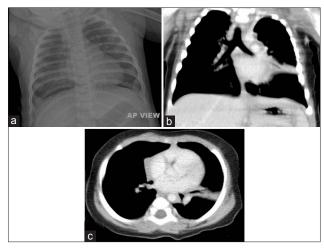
(a) Normal chest radiograph; (b and c) coronal and axial chest computed tomography scan showing hypoplasia of inferior lingular and posterior segment of left upper lobe
